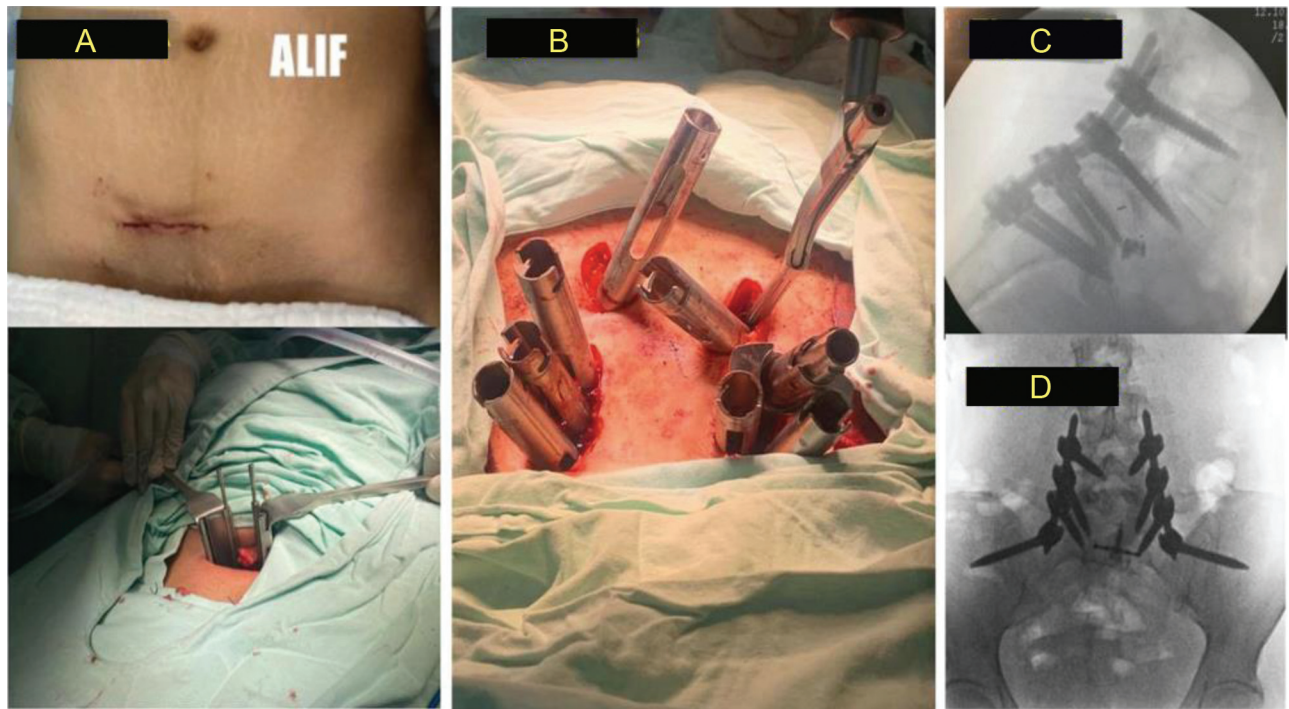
(A) Approach for a mini-open anterior lumbar interbody fusion (ALIF). (B) Minimally invasive posterior approach for arthrodesis. (C,D) Intraoperative radiograph with adequate position of the arthrodesis material and complete reduction of the L5–S1 listhesis.
